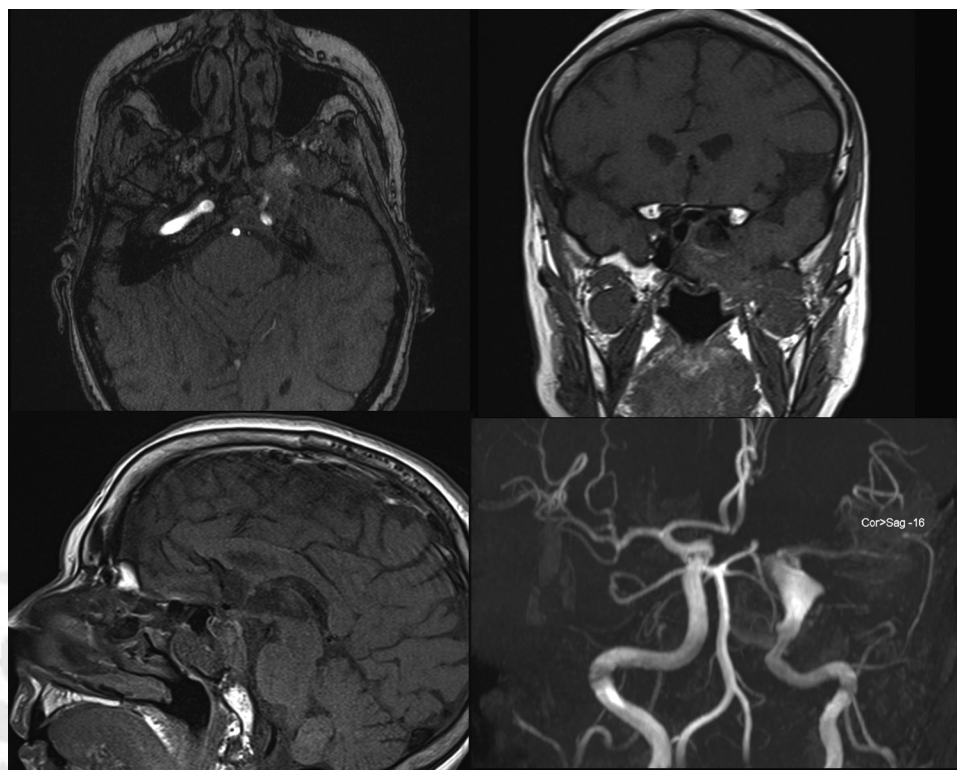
Contrast-enhanced MRI performed 1 year after treatment documents extensive reduction of the mass with disappearance of compression on nerve structures. The aneurysm isolated from the circulation is maintained under observation at follow-up.
